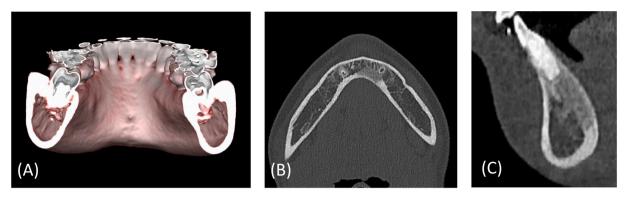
(A) (B) (C) CT imagery after resection for one year which showed bone hyperplasia and disappearance of the defect.
